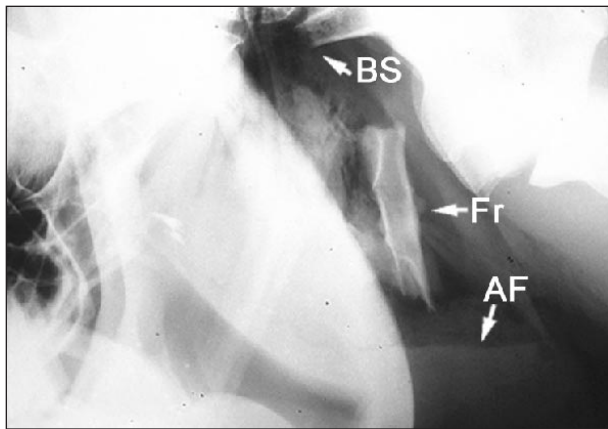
Same radiographic view as in Figure 1. Notice the basisphenoid-basioccipital fracture (BS) and displaced bony fragment (Fr). An air-fluid (AF) interface is also visible.
